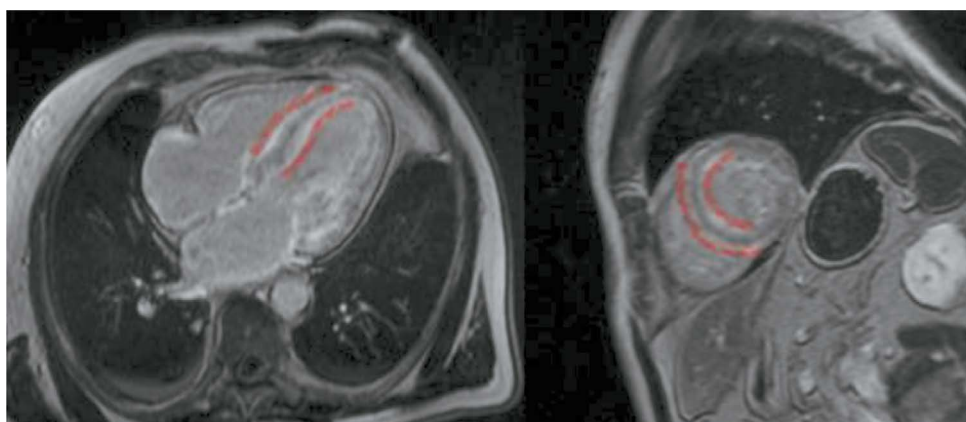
Time-delayed contrast-enhanced cardiac magnetic resonance imaging scans in transthyretin amyloidosis. Subendocardial contrast uptake in the interventricular septum (right and left ventricular involvement) (red dashed lines).
